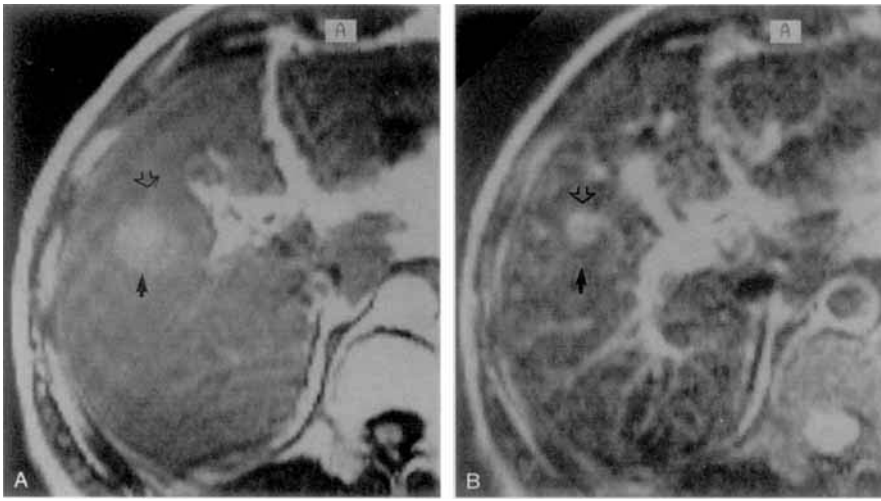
The lesion-liver contrast in the central component is enhanced on both T1- (arrowhead) (A) and T2-weighted MR images (arrowhead) (B) after CSIC administration. The peripheral component is still isointense on the T2-weighted image (arrow) (B), and it is hyperintense on the T1-weighted image but with reduced lesion-liver contrast (arrow) (A).
